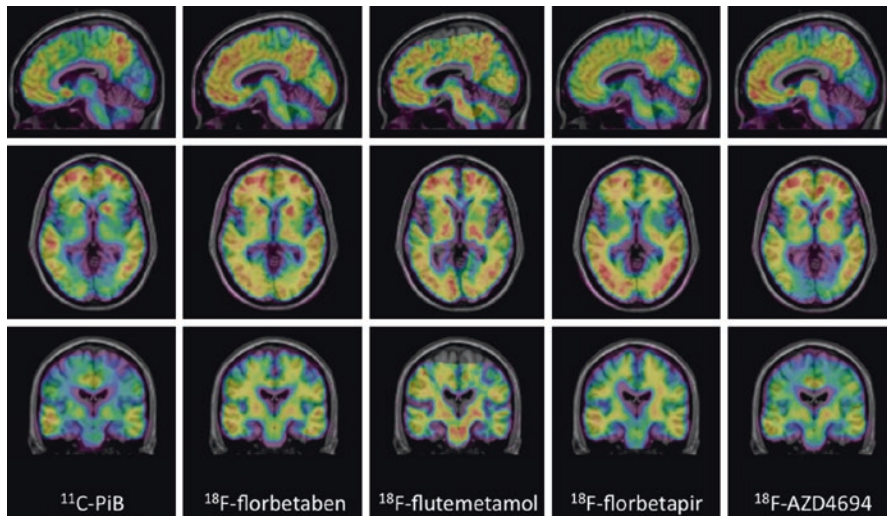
Representative sagittal (top row), transaxial (middle row), and coronal (bottom row) PET images overlaid on MRI from Alzheimer's disease patients obtained with different A β imaging radiotracers. From left to right, ^{11}C -PiB, ^{18}F -florbetaben, ^{18}F -flutemetamol, ^{18}F -florbetapir, and ^{18}F -NAV4694. The images show the typical pattern of tracer retention in AD, with the highest retention in frontal, temporal, and posterior cingulate cortices, reflecting A β plaque burden
